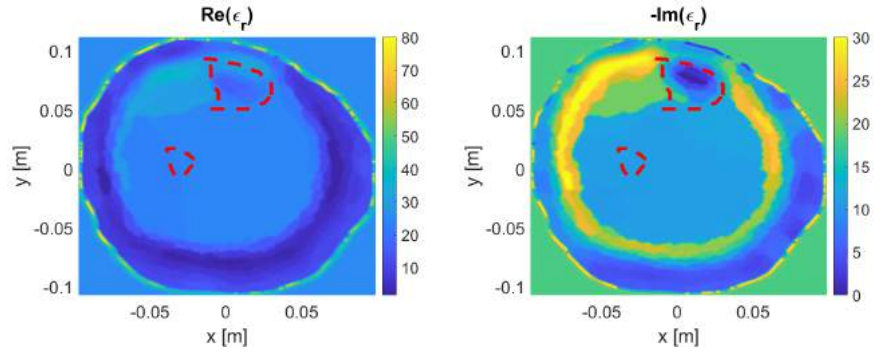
Varying imaging domain to enhance MRI model 1 reconstruction.
